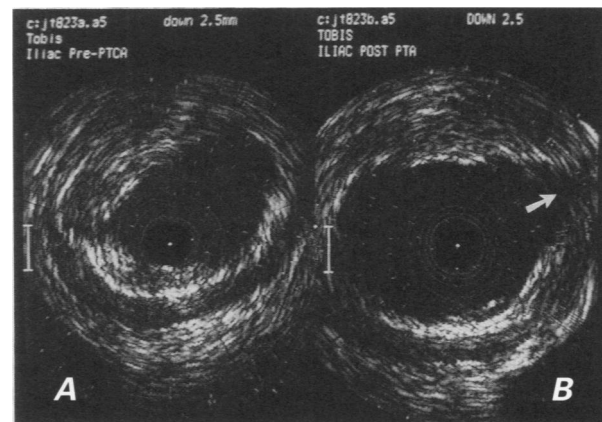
A pair of ultrasonic images obtained before (A) and after (B) dilation of a moderately diseased artery. The images were obtained 2.5 mm below the needle reference line. The central black area marks the site of the transducer. In A), the echo-free lumen is clearly delineated from the fibrous, atheromatous plaque, which has high echo reflectance. The muscular media has low echogenicity, and the surrounding adventitia shows high echo reflectance. After balloon dilation (B), the cross-sectional area was increased and there was a minor tear in the plaque (arrow).
